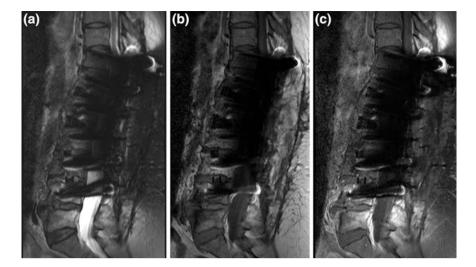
Susceptibility artifact on sagittal images of the lumbar spine in a patient with spinal fixation hardware. Sagittal plane images from an MRI study of the lumbar spine demonstrating significant susceptibility artifact in this patient with metallic spinal fixation hardware, with associated image distortion and obscuration of the field of view (compare with Fig. 11, lumbar spine images from a different patient). a T2, b precontrast T1, and c post intravascular contrast administration images
